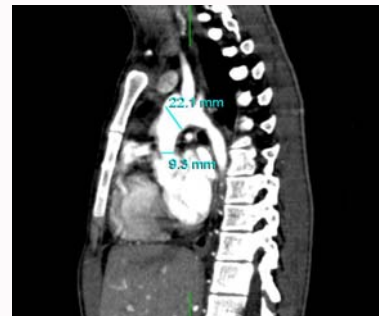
Multiplanar reconstruction image shows the diffusely stenosed ascending aorta in computed tomographic angiograms.
